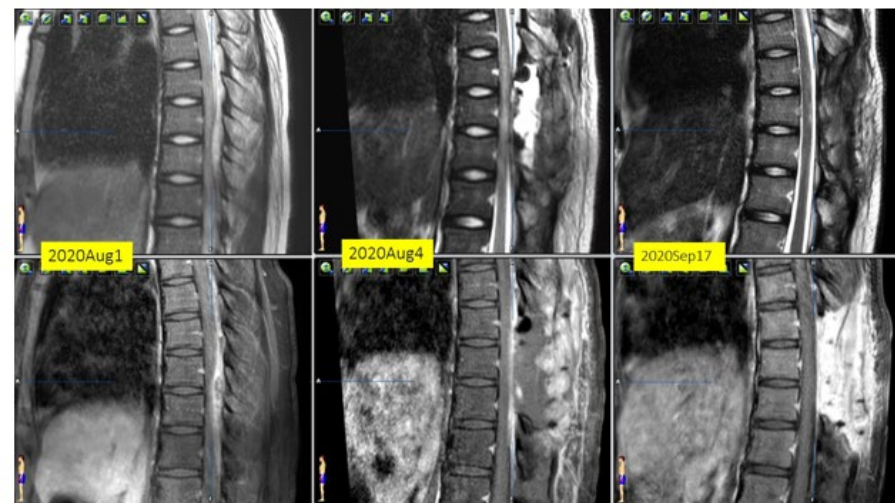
Interval MRI showing resolution of spinal epidural abscess and no recurrence after completion of course of antibiotics
